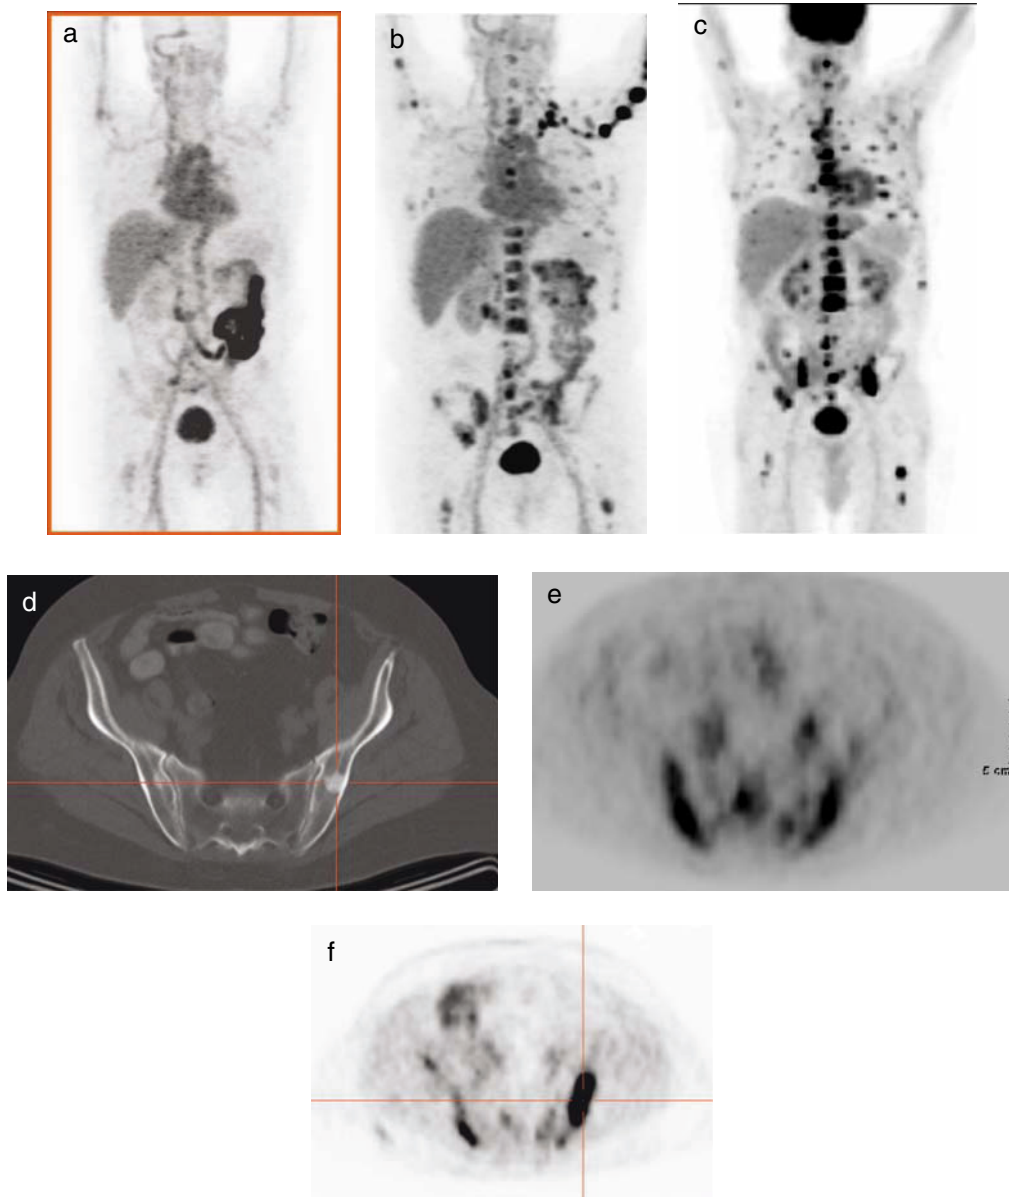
Biodistribution of FDHT and FDG in metastatic prostate cancer. (A) Normal distribution of FDHT showing blood pool, hepatobiliary, and urinary tracts. (B, C) Maximum intensity projection images showing uptake of FDHT (B) and FDG (C) in osseous metastases from prostate cancer. (D) Transaxial CT image shows sclerotic metastasis in left iliac bone (*cross hairs*) and smaller lesion in the right iliac bone. (E–F) Transaxial FDHT (E) and FDG (F) images reveal abnormal radiotracer accumulation in pelvic bones that far exceeds the structural abnormality seen on CT, which indicates spread of metastasis throughout the bone marrow not detectable on CT.
